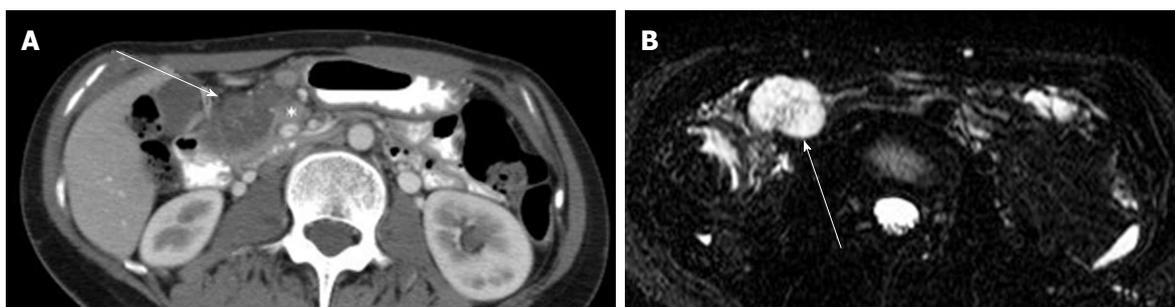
A 32-year-old female with lymph node metastasis from mucinous adenocarcinoma of the transverse colon (not shown). A: The portal venous phase of an axial computed tomography shows a low density mass (arrow) adjacent to the pancreatic head (asterisk); B: Axial magnetic resonance cholangiopancreatography shows the mass to be high intensity, mimicking microcystic serous cystic neoplasm (SCN). However, the presence of primary tumor and the lesion location (transverse mesocolon) are suggestive of lymph node metastasis rather than microcystic SCN.
